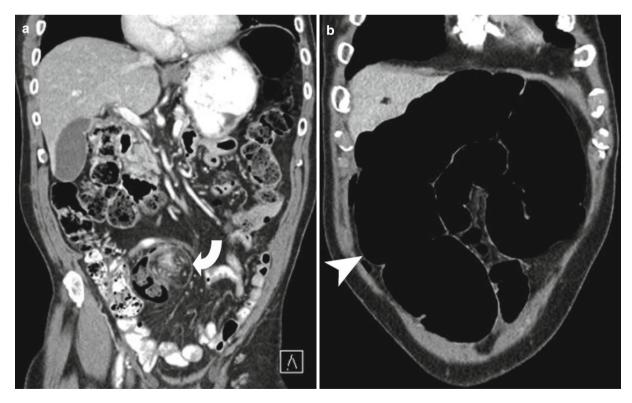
Cecal volvulus. (a) Coronal CT reformation demonstrates whirled appearance of the mesentery as well as a segment of the right colon in this patient with cecal volvulus. (b) Coronal CT reformation
